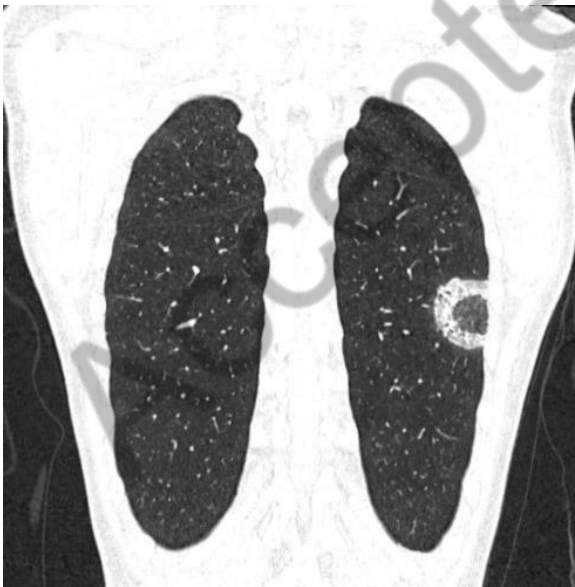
CT-scan (coronal plane) showing a subpleural consolidation with a reversed halo sign image (ground glass center with a surrounding consolidation) in the left lower lobe
